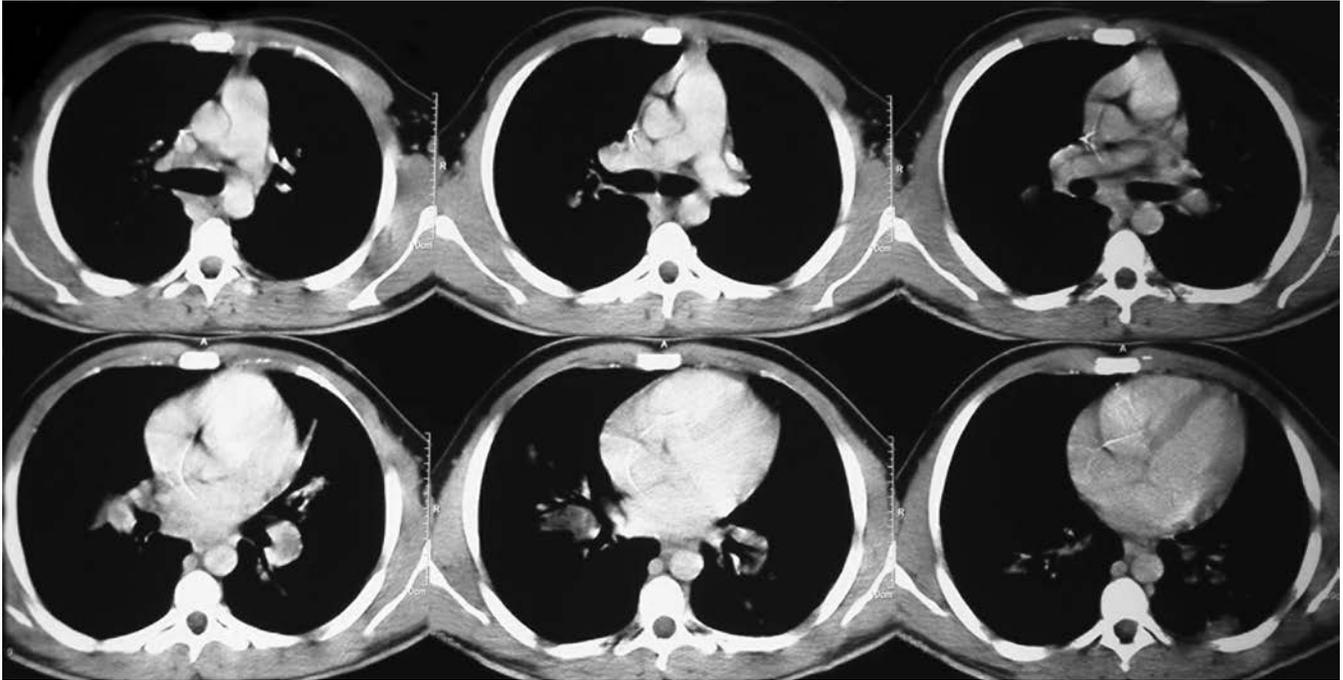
CT scan showing a catheter-like image in the right heart coming from the superior vena cavae.
